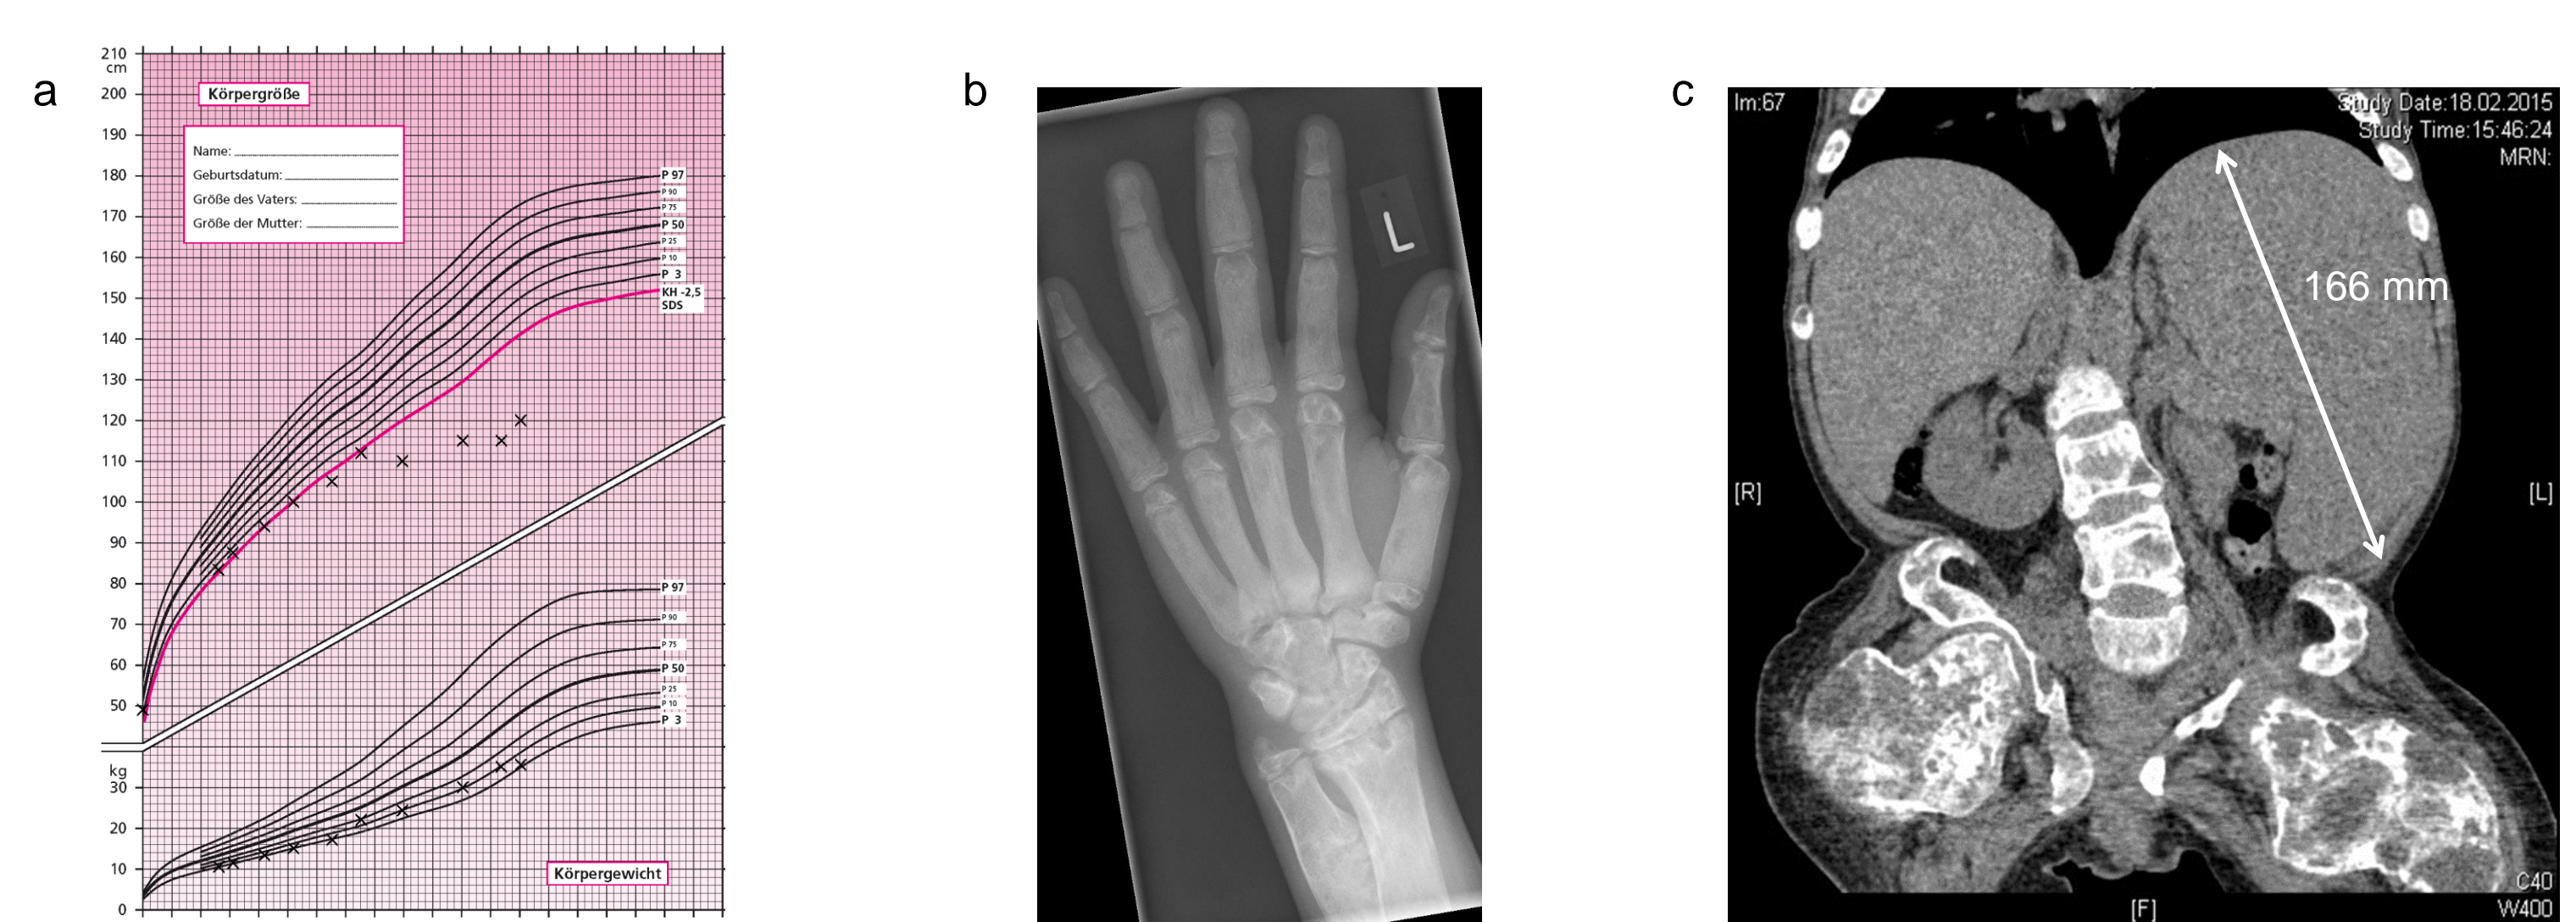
a) growth curve of the patient b) X ray of the left hand at the patient age of 9 years with accelerated bone age of 13 years and lytic changes of the bone structure c) abdominal CT reveals massive splenomegaly at age 15
